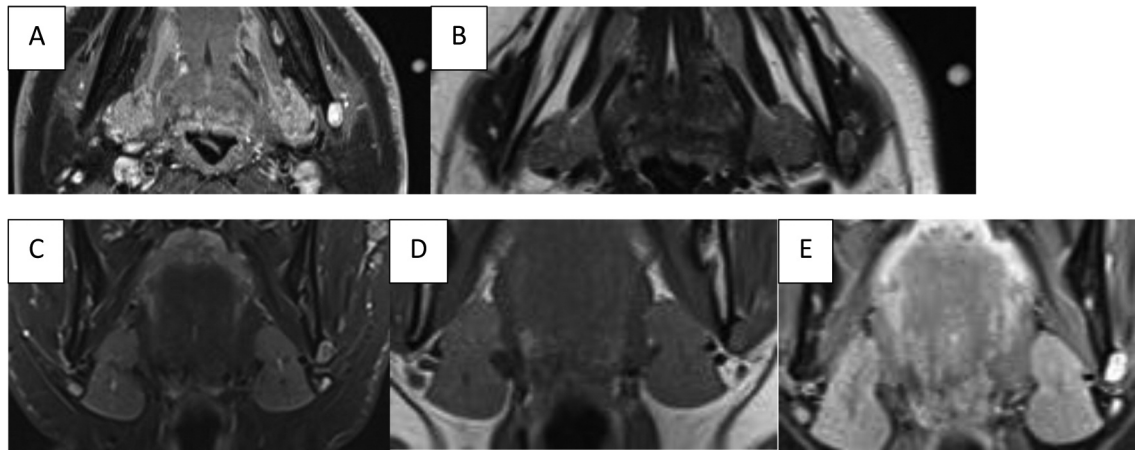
Magnetic resonance images (MRI) of the left mandibular lesion. A) Axial section. Hyperintense lesion of oval shape in left mandibular angle [T1 fat suppressed Dixon method (FS-Dixon)]. B) Axial section. Incomplete, narrow hyperintense margin of the lesion. This narrow hyperintense border is marked more clearly on the T2-weighted coronal image depicted in C), whereas the lesion is homogeneously isointense to muscle on T2 weighted turbo-spin echo (TSE) coronal image shown in D). E) Coronal image of the lesion on TSE (FS-Dixon) weighted image.
